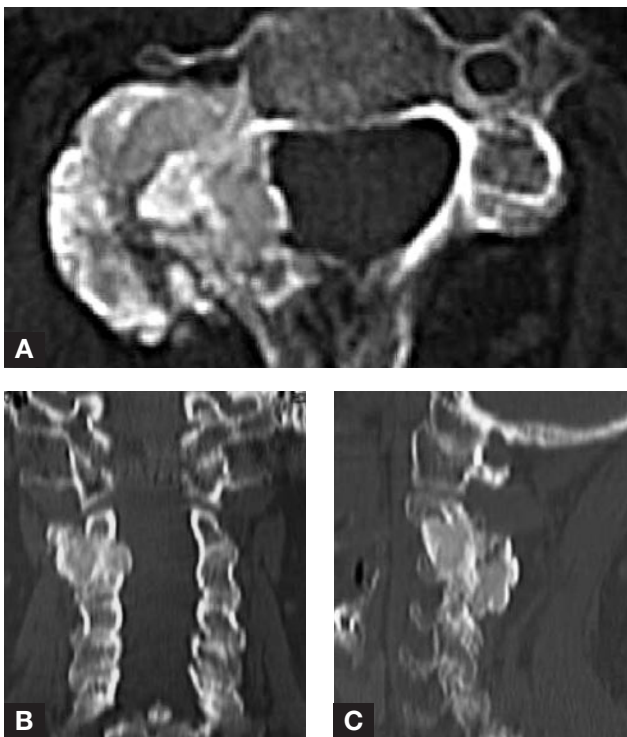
Axial (A), coronal (B), and sagittal (C) computed tomography scans show large calcified mass (with sclerotic rim and slight intraspinal extension) at right C2-C3 facet joint, pedicle, and lamina.
